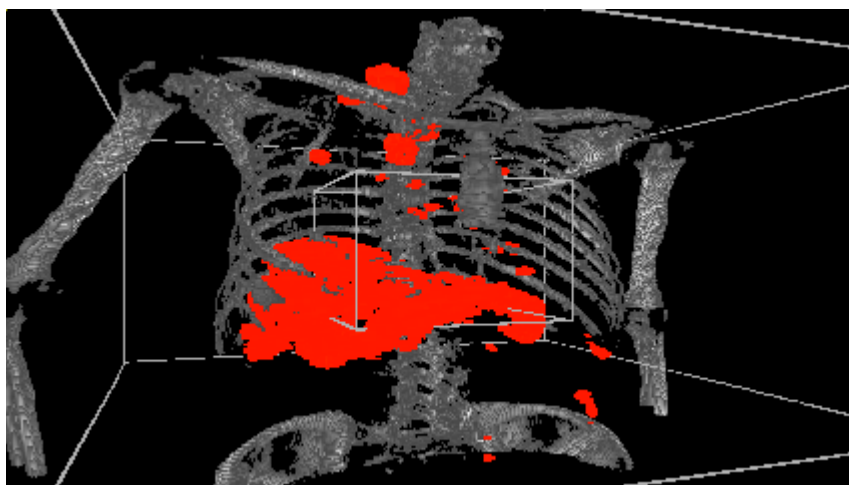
Result with overlapping SUV projection.
